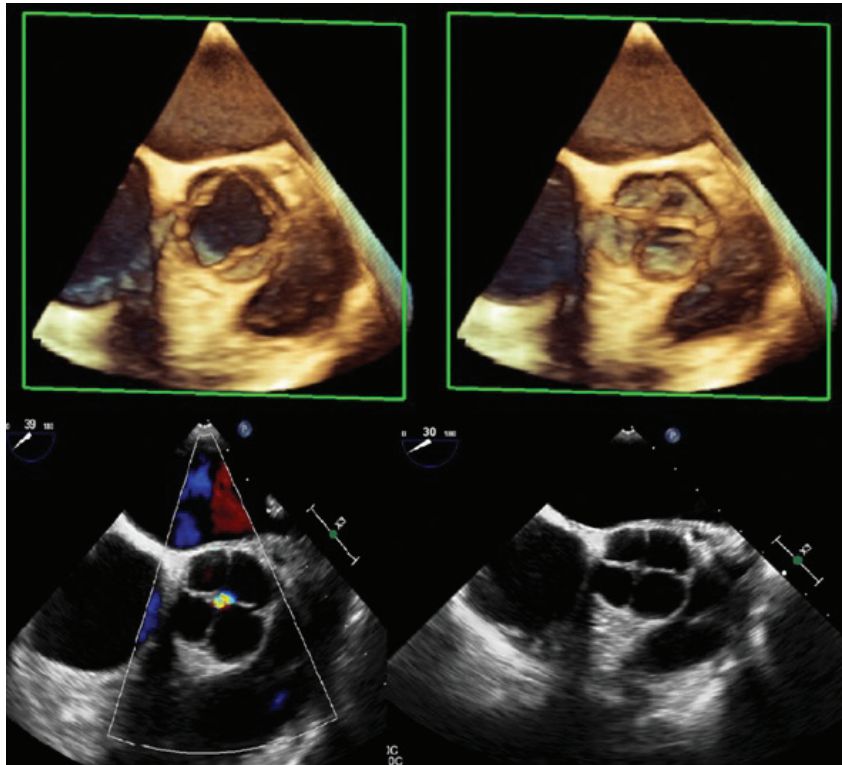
Two-dimensional and real-time three-dimensional transesophageal echocardiography demonstrating a quadricuspid aortic valve with four equal-sized cusps and mild aortic regurgitation.
